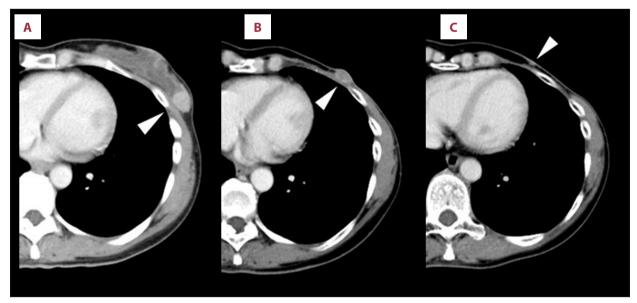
Primary breast cancer and recurrent lesions on E-CT imaging. E-CT on July 2007 (A) showed the primary breast cancer (white arrowhead). E-CT at 3 years and 8 months (B) and 4 years and 4 months (C) after the first surgery revealed the recurrent lesions (white arrowheads) in the left chest wall.
